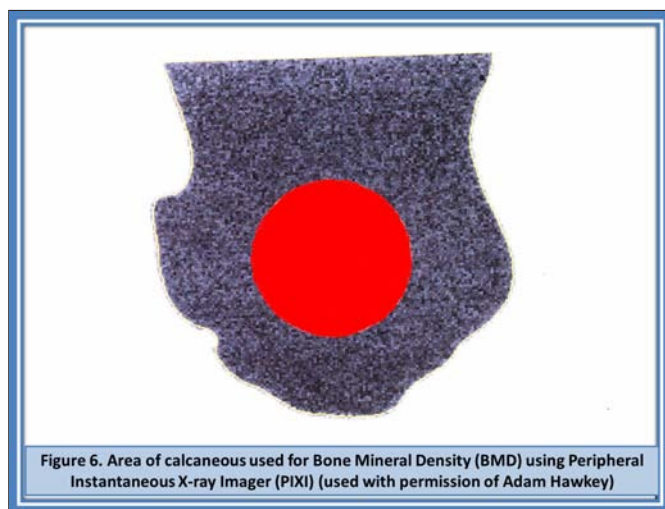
Clinical assessment of calcaneal bone mineral density (BMD) with Peripheral Instantaneous X-ray Imager (PIXI) equipment (used with permission of Adam Hawkey)
